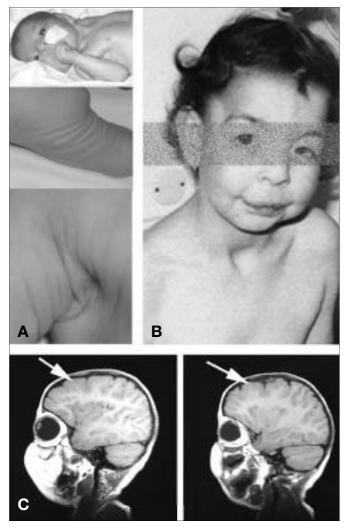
(A) Facial and skin features of cutis laxa at 3 months, (B) facial features at age 5 years, (C) frontal pachygyria on cranial magnetic resonance imaging at age 4 years.
